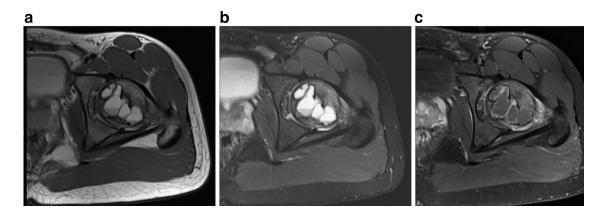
MRI with and without gadolinium enhancement. Axial views of PD (A), stir (B) and FS postcontrast (C) sequences depicting a femoral head multi-cystic lesion with narrow zone of transition, irregular margins, fluid-fluid levels and peripheral enhancement.
